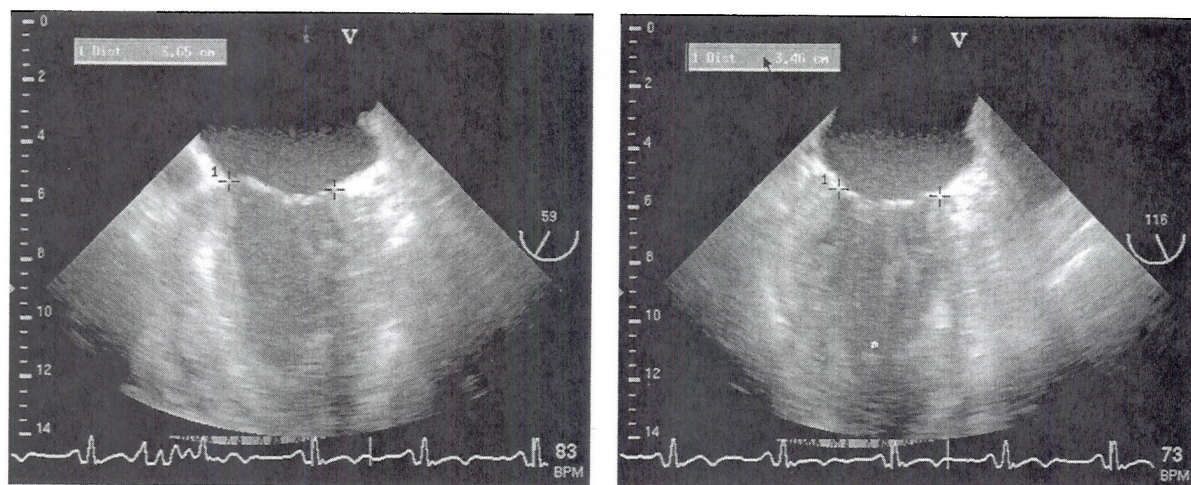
Transesophageal echocardiographic images used to measure mitral annulus in two planes: the mid-esophageal commissural view (left) and the mid-esophageal long-axis view (right). Note the electronic calipers indicating the measurements of the mitral annulus "length" (left) and "width" (right).
